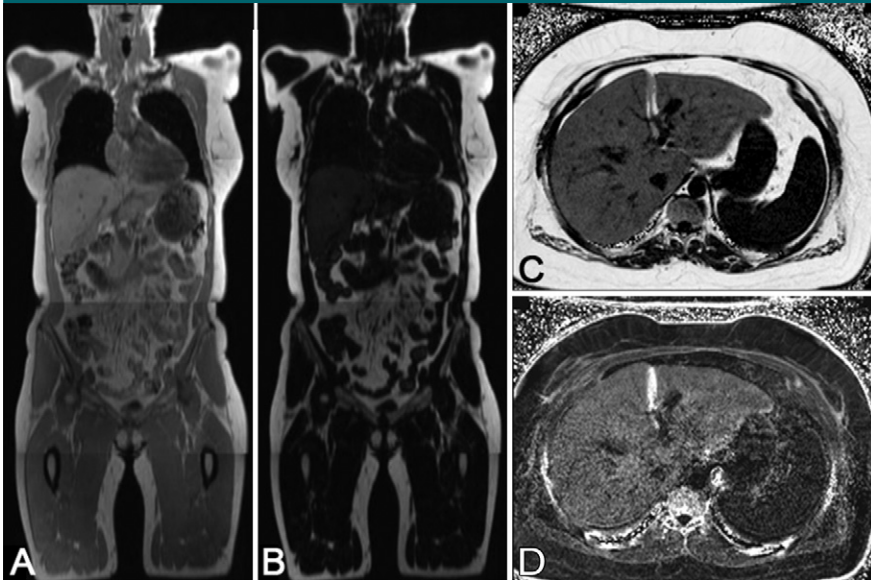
Image examples as part of the thoracoabdominal MR imaging protocol: *A*, T1-weighted 3D volumetric interpolated breath-hold examination (VIBE) image from the neck to the knees with coronal reconstructed images. *B*, Body fat can be assessed with the two-point Dixon-technique separated fat images. *C, D*, Multiecho VIBE images with six echoes yield percentage-scaled fat (*C*) and $R2_{\text{eff}}$ (*D*) images of the liver.
